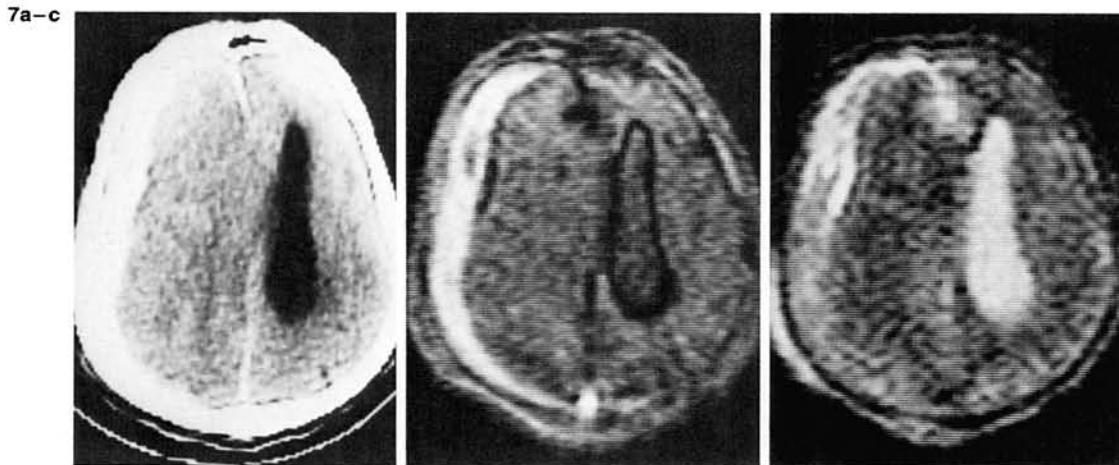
Acute subdural hematoma is hyperdense on CT scan (a), is clearly discernible in inversion recovery 1,000(200)/70 image (b), and shows a medium intensity in the spin echo 2,000/160 image (c) at 0.02 T.
